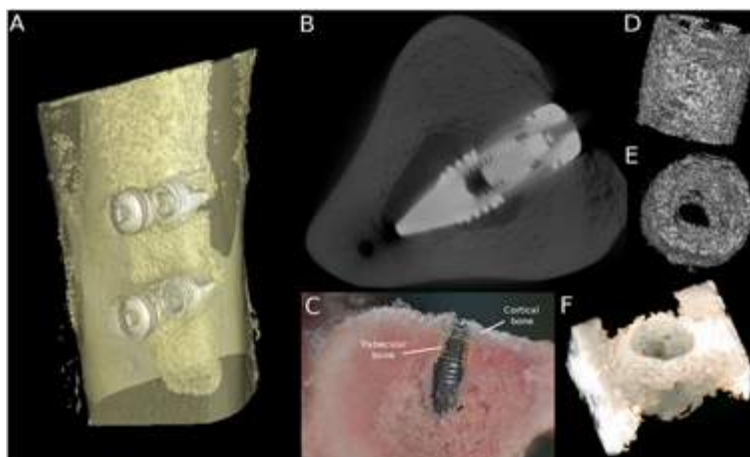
(A) High-resolution μ CT 3-D volume rendering of minipig tibias with implants. (B) Representative axial μ CT image of minipig tibias with implant–bone interface visualization. (C) Representative photograph of minipig tibias with implant position visualization. (D and E) High-resolution μ CT 3-D volume rendering of scaffold. (F) High-resolution μ CT 3-D volume rendering peri-implant bone.
